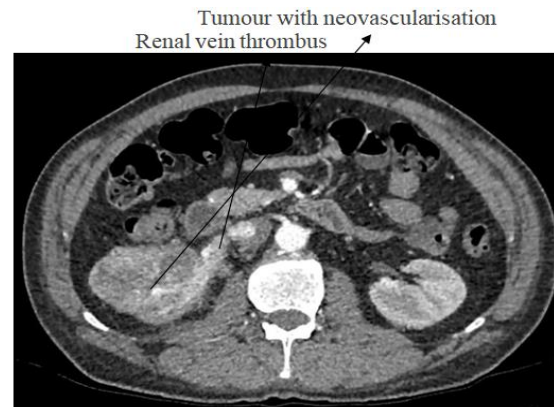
An arterial phase CT will show enhancement of a tumour thrombus due to neovascularisation of the tumour, as in this case.
